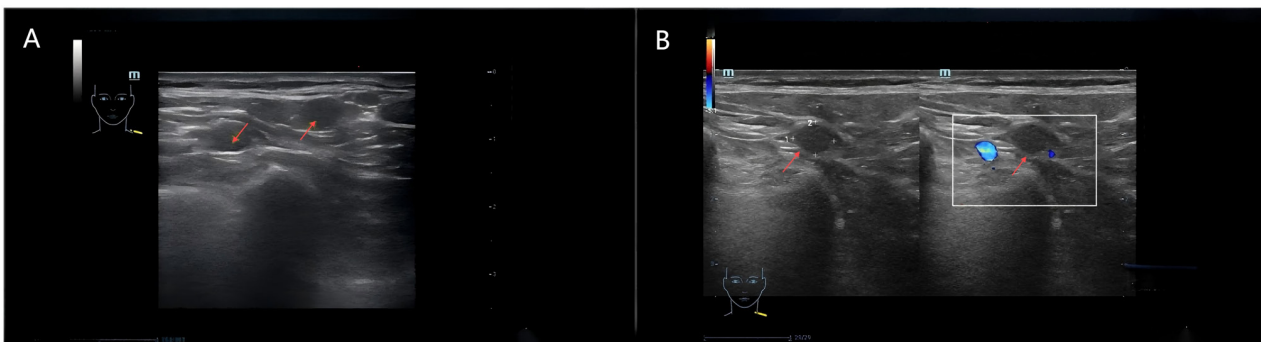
Lymph node ultrasound showed multiple abnormal lymph nodes in both sides of the supraclavicular fossa (arrows indicate the abnormal lymph node). (A) Two-dimensional ultrasonic image. (B) Image combining two-dimensional ultrasound and color Doppler ultrasound.
